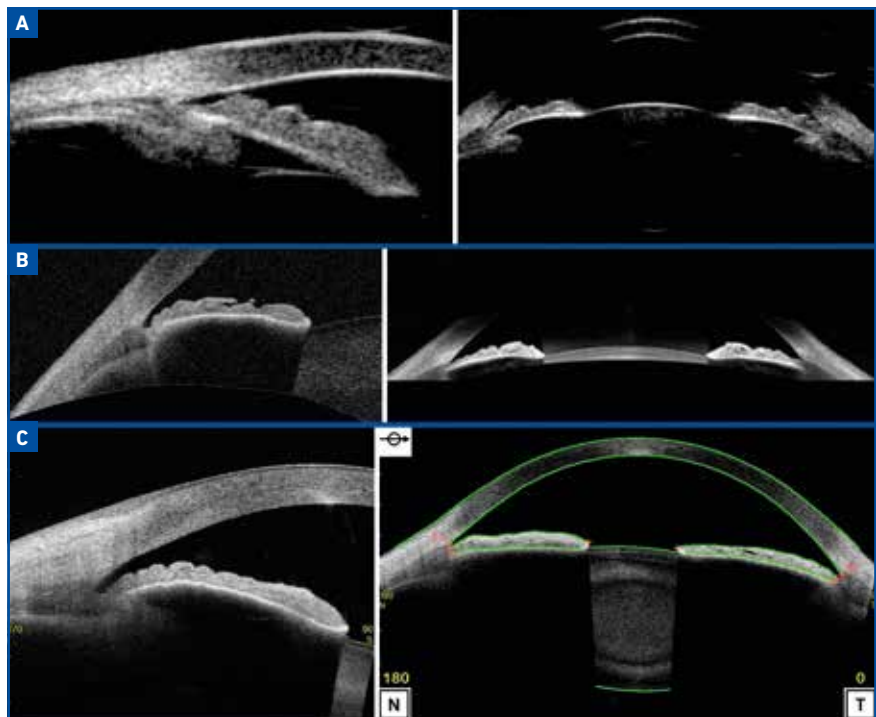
Ultrasound sections in UBM showing the perfect visualisation of the structures of the anterior segment and, in particular, of structures behind the iris. B: sections of the anterior segment in retinal OCT with anterior segment modulus. Note the high quality of the images at the cornea but the absence of visualisation of structures behind the iris. C: sections of the anterior segment from an OCT of the anterior segment (with specific wavelength) giving even higher precision at the cornea but still with absence of visualisation behind the iris.
